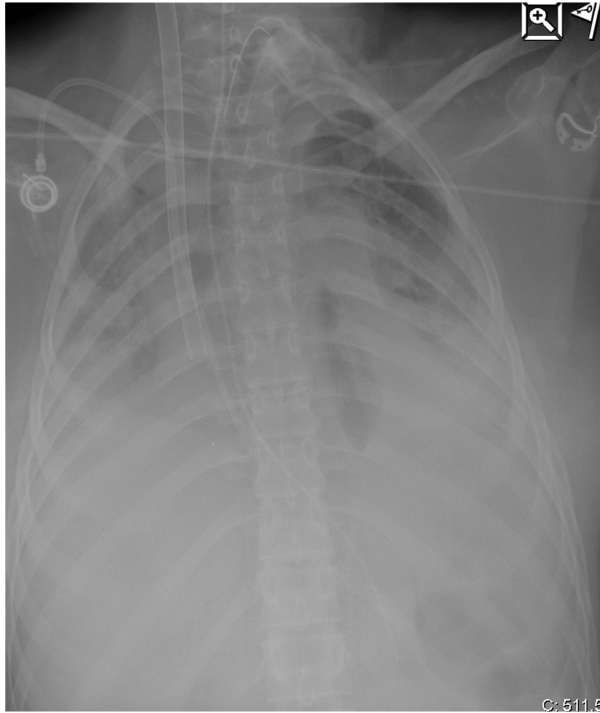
A frontal chest X-ray investigation from day 7. The patient has been tracheostomized, and the subcutaneous and mediastinal emphysemas as well as pneumothoraces are all reabsorbed. "White-out", water-soaked lungs, signs of pleural fluid, and/or larger atelectasis are evident bilaterally. At this point of the clinical course, the tidal volumes were 80 mL. Thus, the patient is virtually totally ECMO dependent.
